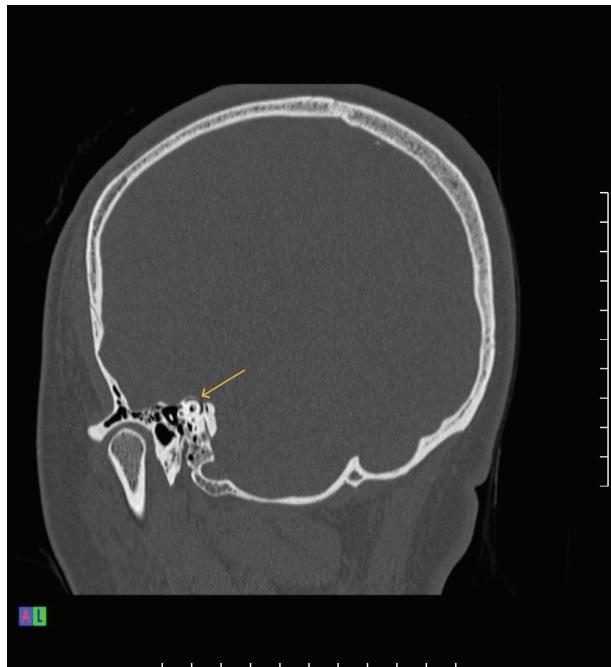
Superior semicircular canal dehiscence in Stenvers view. Coronal CT reconstruction in the Stenvers plane of the same patient reveals a defect in the bony roof of the superior semicircular canal (arrow).
